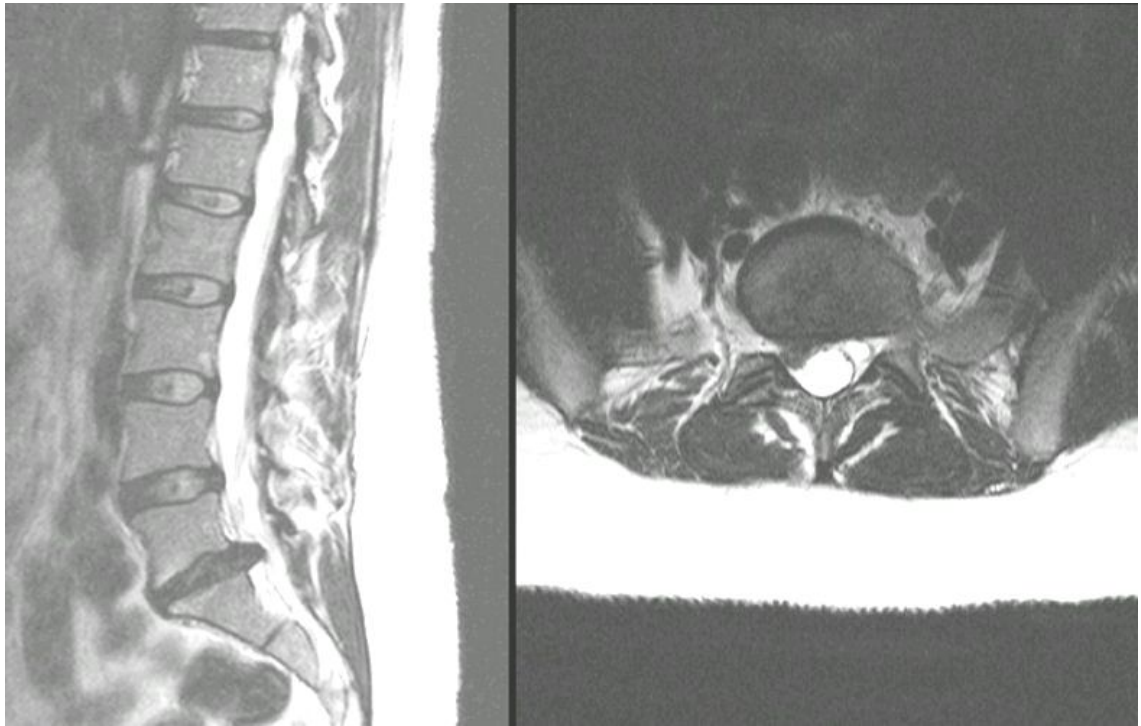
sagittal and axial T2 Weighting MRI image with disc prolapse.
